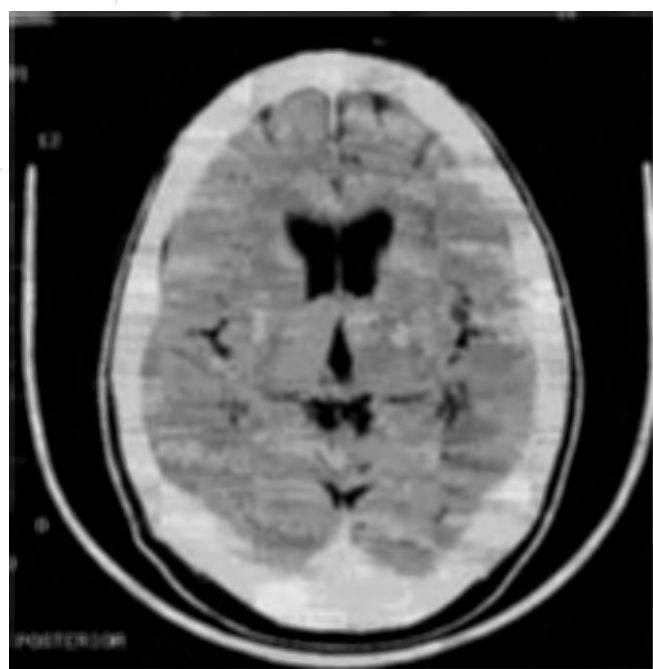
Post-treatment contrast-enhanced CT scan of the same patient showing resolution of the oedema, decrease in contrast uptake and residual hypodensity.
